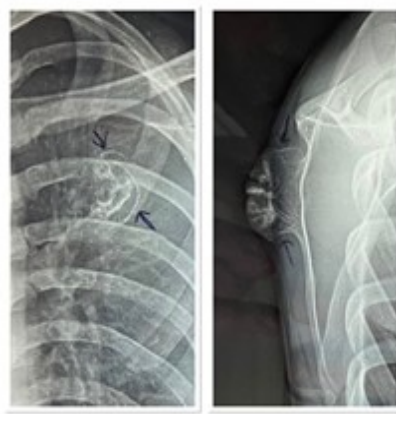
Pre-operative right scapula X-ray in anteroposterior and lateral view showing pedunculated mass arising from the posterior medial aspect of the left scapula.
